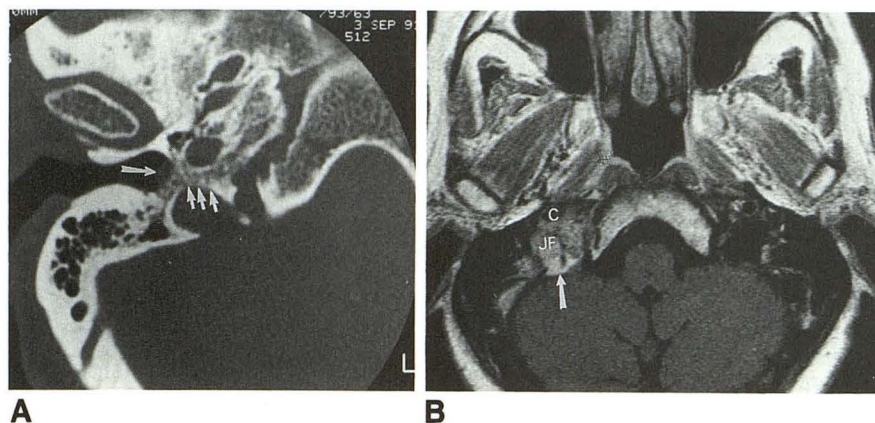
A, Axial CT of a jugulotympanic tumor imaged with bone algorithm demonstrates osteopenia between the jugular fossa and the carotid canal with erosion of the cortical bone of the fossa (*small arrows*) associated with a mass protruding into the middle ear cavity (*large arrow*).
